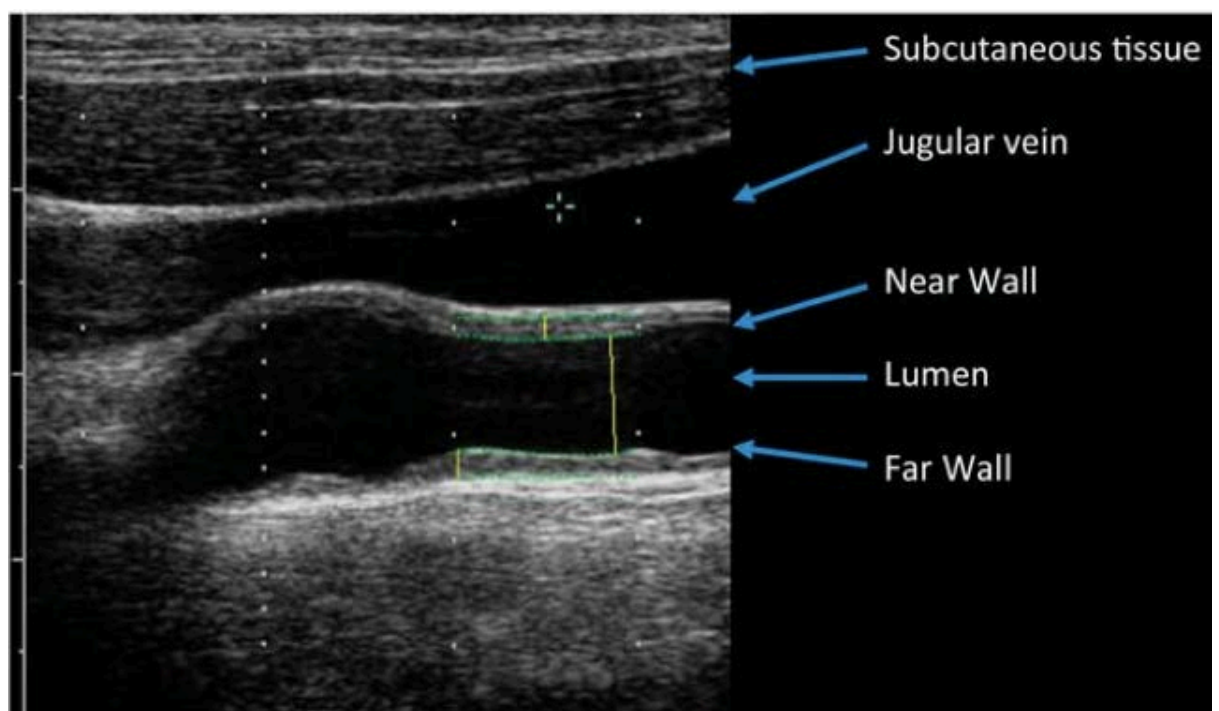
B-mode sonography of common carotid artery showing near wall and far wall. (Adapted from O’Leary and Bots, 2010)
